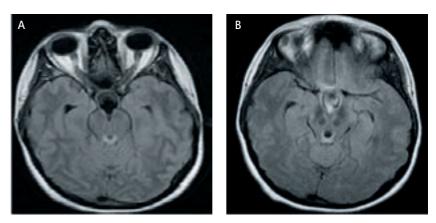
FLAIR-weighted MRI scans prior to (A) and after (B) ETV. The turbulent flow pattern in the anterior third ventricle indicates a patent stoma.*
